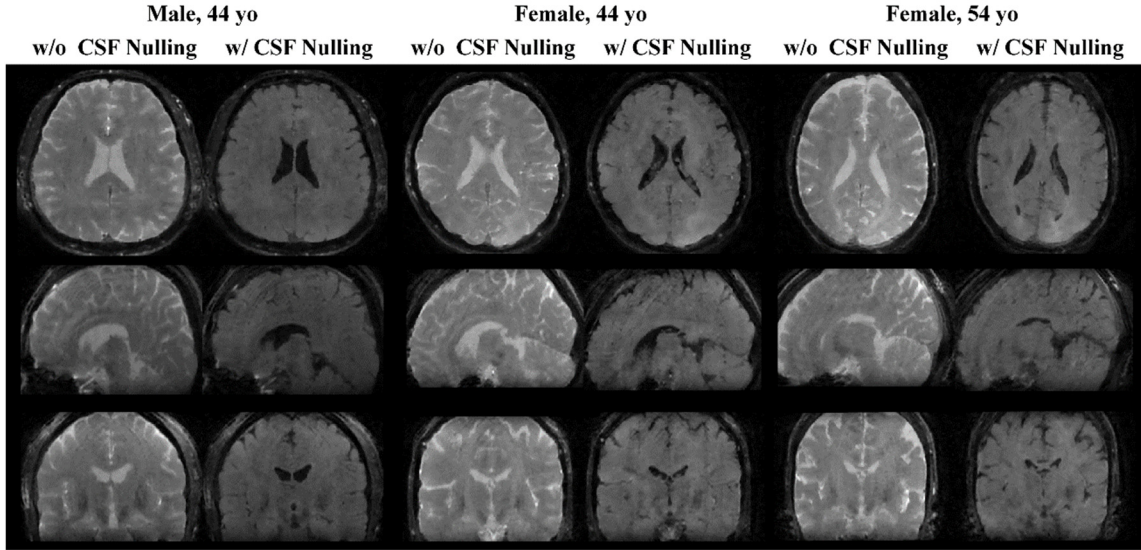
Whole-brain cross-sectional T2-weighted images ($TE_{\text{prep}} = 80$ ms) in axial, sagittal, and coronal views of three healthy volunteers estimated by pulse sequences with and without CSF nulling, using the rotated spiral trajectories and the model-based CS-incorporated reconstruction method with an in-plane 5-fold acceleration.
